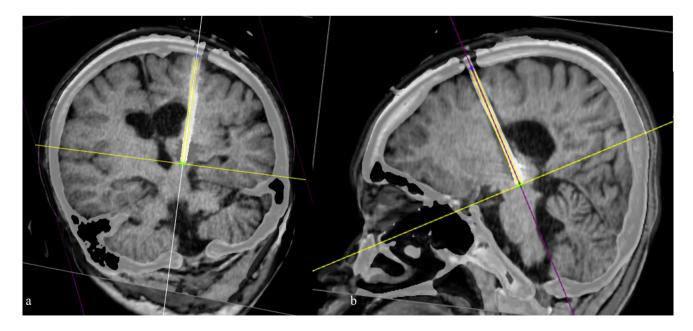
T1-weighted MRI coronal (a) and sagittal (b) sections representing the trajectory plans of patient no. 1
